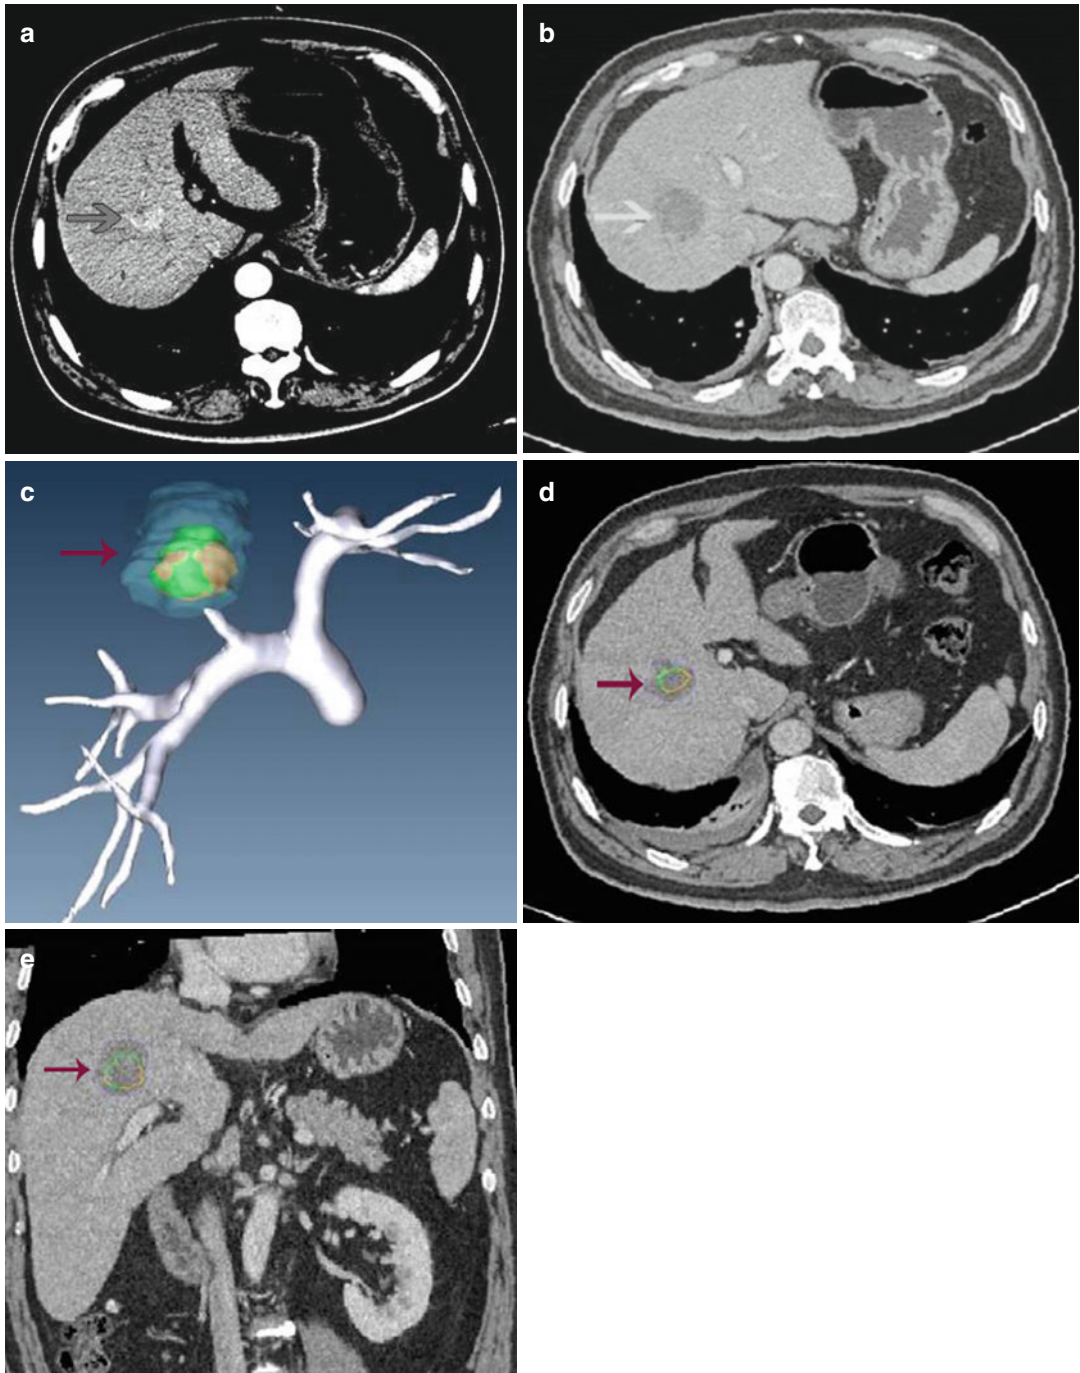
Images before and after ablation therapy and 3D visualization curative effect evaluation results. (a) Preoperative enhanced CT showed right anterior lobe of the liver mass (*arrow*); (b) ablation zone (*arrow*) was unenhanced after ablation; (c) 3D visualization image showed ablation efficacy of the ablation zone covering the original tumor (*arrow*). Green area
